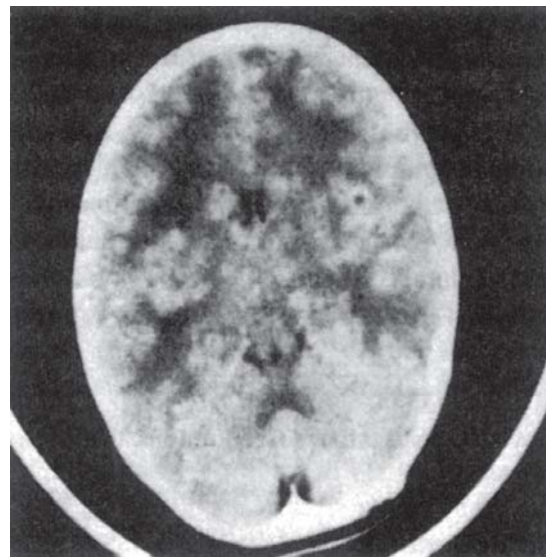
CT scan showing cerebral abscess in left frontal lobe
